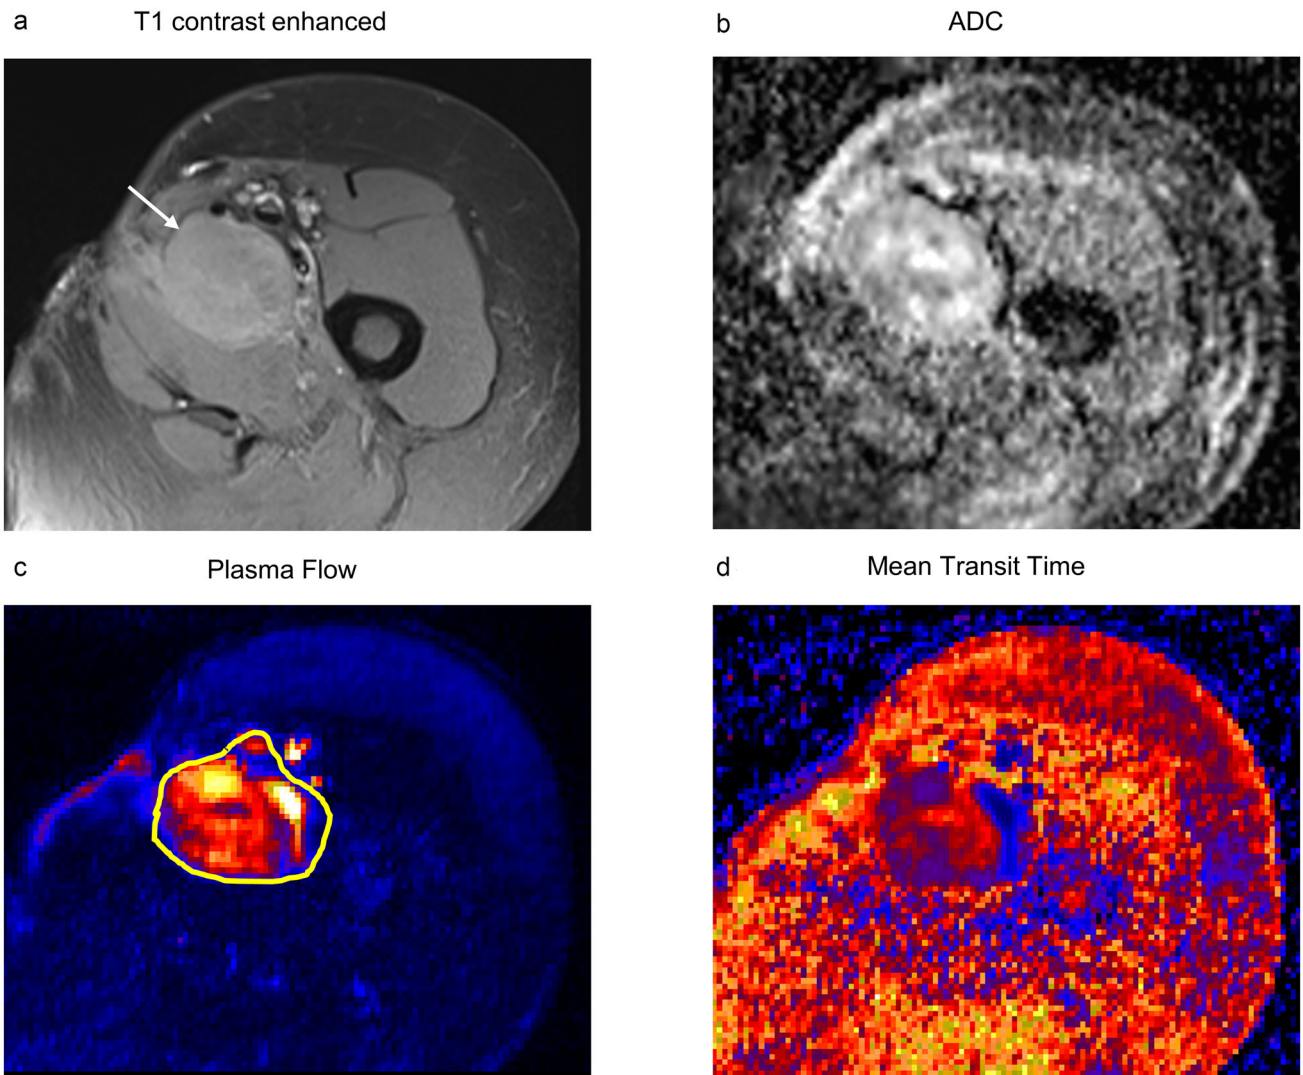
Images of a 70-year-old patient with G3 liposarcoma and local recurrence of STS in the groin. (a) Contrast-enhanced T1-weighted image. White arrow shows slight enhancement of the lesion. (b) ADC-map. (c) Plasma flow. In local recurrence, plasma flow is markedly increased compared to surrounding tissue; (d) mean transit time in local recurrence is slightly decreased.
